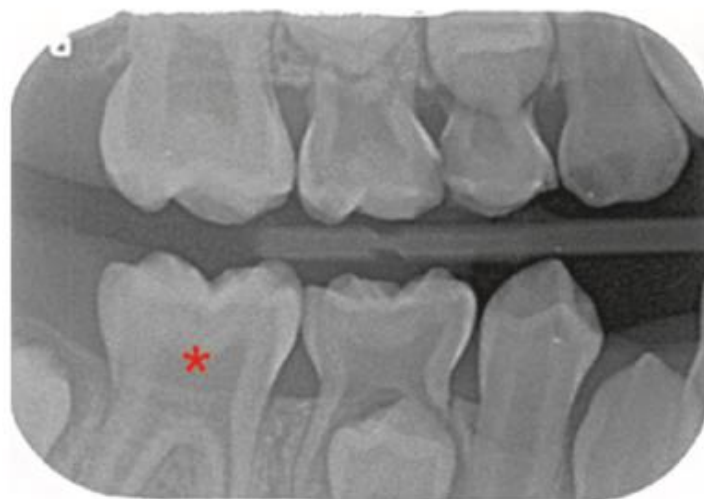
Periapical radiographs of primary dentition showing irregular circumpulpal dentine (Paredes et al., 2018)*
